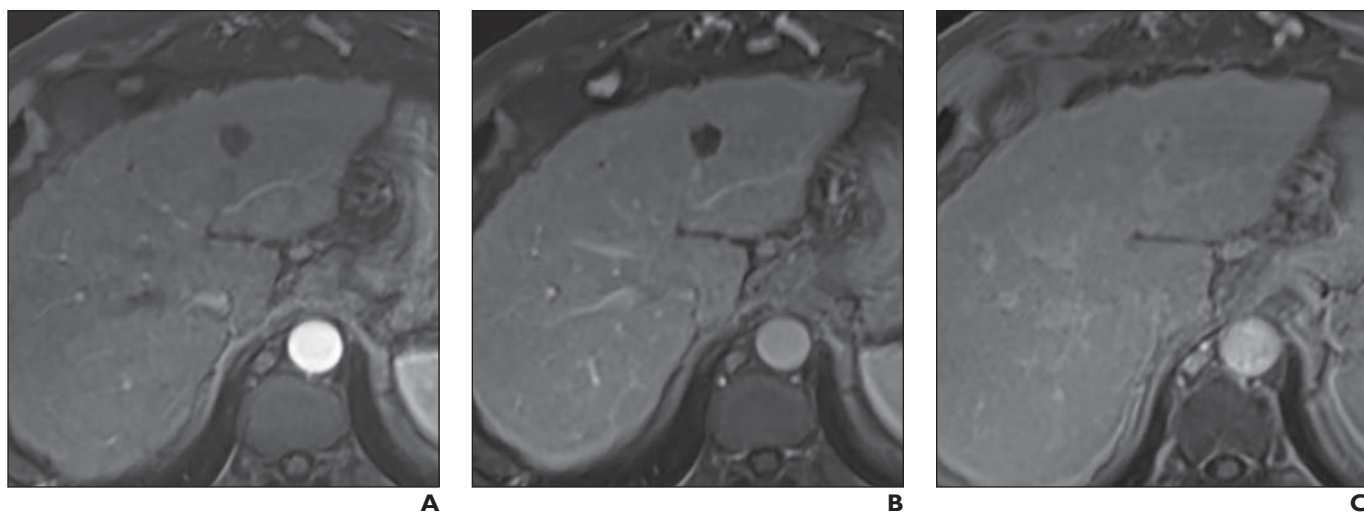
68-year-old man with cirrhosis. Example of hemangiomas with atypical enhancement patterns. Well-defined lesion in segment II had high signal intensity on T2-weighted MR images (not shown), low signal intensity on T1-weighted images (not shown), and minimally nodular enhancement on several immediate contrast-enhanced images with definite central filling in on late-phase images. This pattern of enhancement may be seen in both noncirrhotic and cirrhotic livers.
